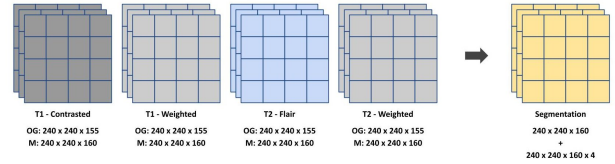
Four-channel input tensor (T1, T1CE, T2, and FLAIR); and One-channel of the Output Tensor (Annotated Segmentation); as provided by the dataset
